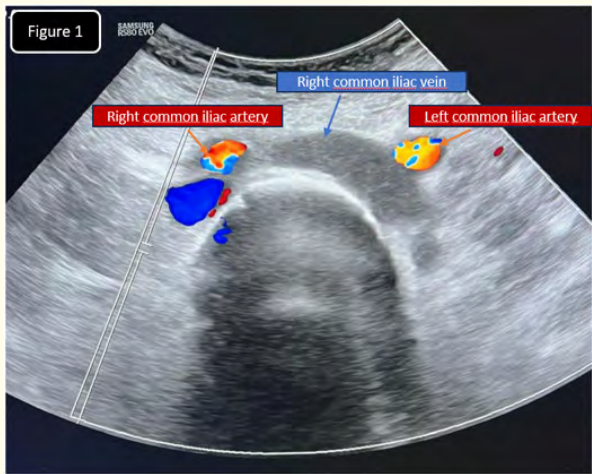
Color Doppler ultrasound image the right common iliac artery is seen crossing over the left common iliac vein, which is not visualized here due to compression, consistent with May-Thurner (Cockett) syndrome.
